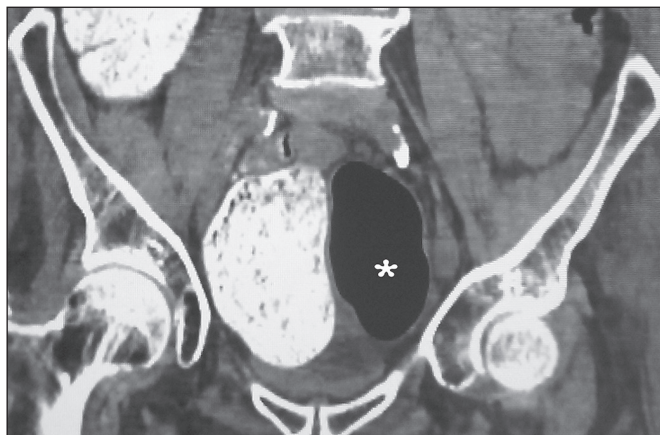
A 58-year-old man who engaged in sexually self-destructive behaviour by inserting an inflated balloon into the urinary bladder through the urethra. Coronal reformatted CT image of the pelvis shows the partially deflated balloon (asterisk). The large bowel is filled with an oral solution of gastrografin.
